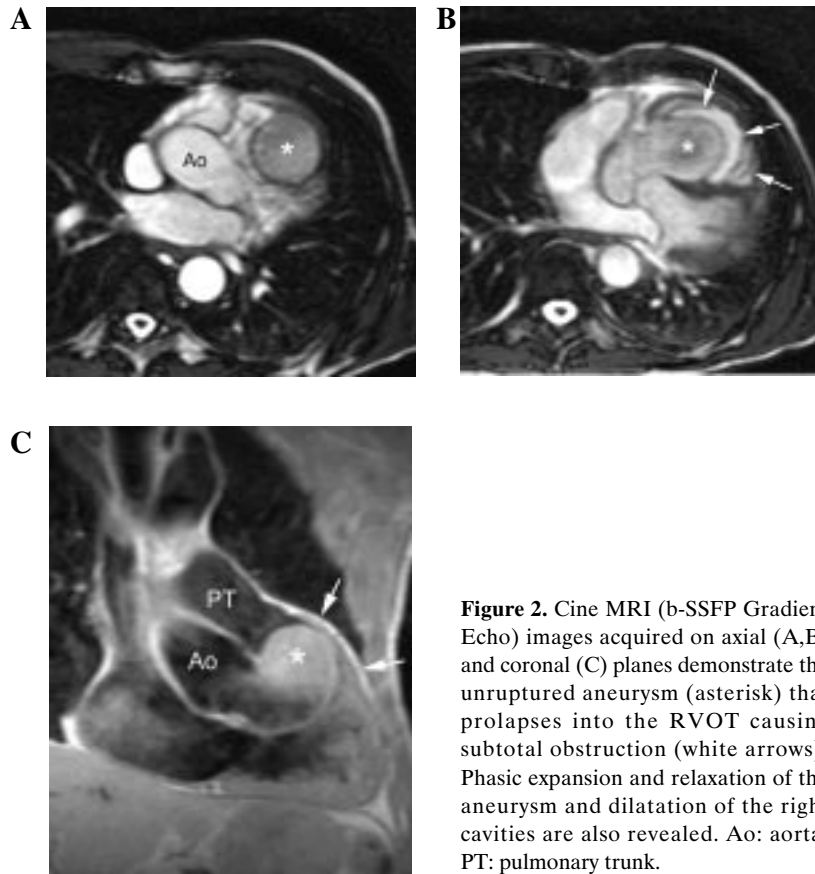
Cine MRI (b-SSFP Gradient Echo) images acquired on axial (A,B) and coronal (C) planes demonstrate the unruptured aneurysm (asterisk) that prolapses into the RVOT causing subtotal obstruction (white arrows). Phasic expansion and relaxation of the aneurysm and dilatation of the right cavities are also revealed. Ao: aorta; PT: pulmonary trunk.
